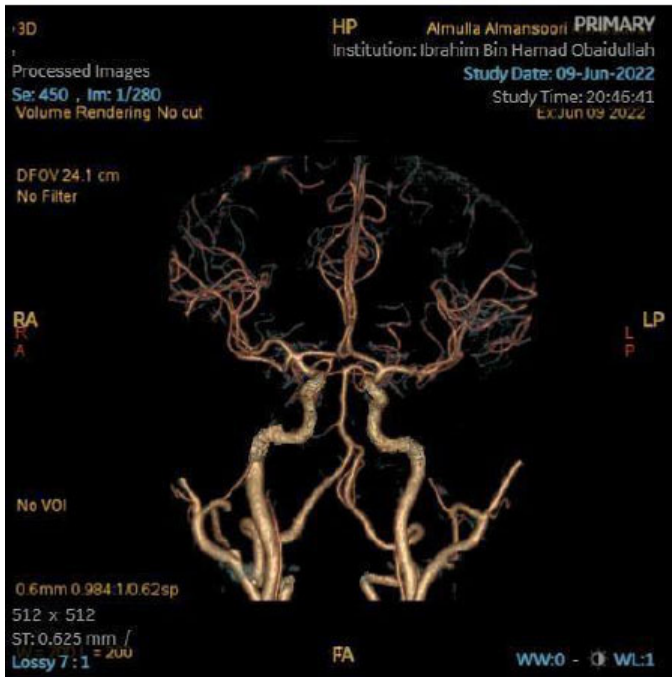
CT angiography head w/ + w/o contrast results of the patient, showing normal CTA angiography of the extra and intracranial carotid and vertebrobasilar arterial systems study with no evidence of arterial dissection.
